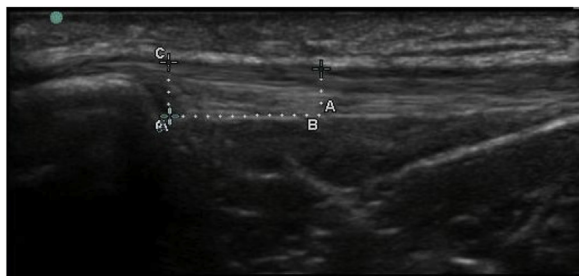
Sonographic image of measurement site (AP & 1uAP).
